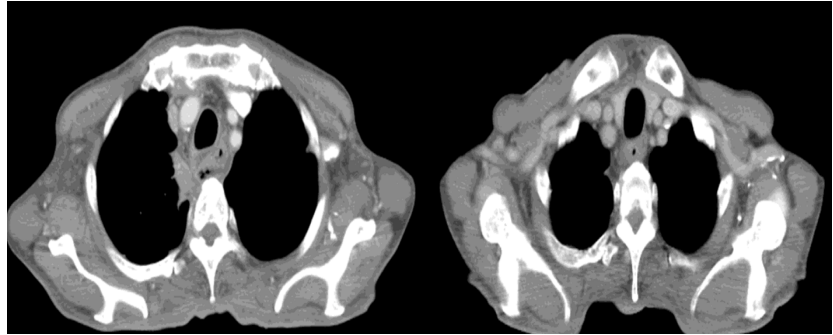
Radiographic comparison of Chest CT scan: Left panel, image from admission, right panel, image from 4 weeks of antibiotic therapy. On Admission, rim-enhancing, hypodense collections with intralesional air foci located in the right paratracheal and paraesophageal regions at the T1 to T4 levels. The collection measured $5.3 \times 1.7 \times 2.7$ cm (craniocaudal \times width \times anteroposterior), with a calculated volume of 12.7 cc. After 4 weeks of Intravenous antibiotics, with complete resolution of rim-enhancing collection in the right paratracheal and paraesophageal regions.
